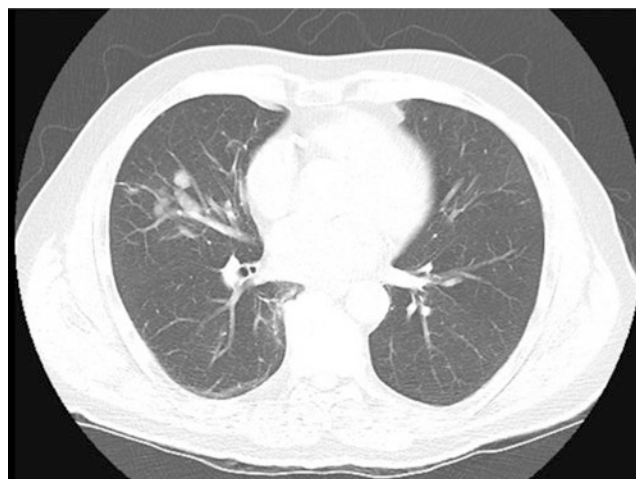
Computed tomography (CT) of the chest image for multiple nodular lesions on the right involving middle and lower lobes
